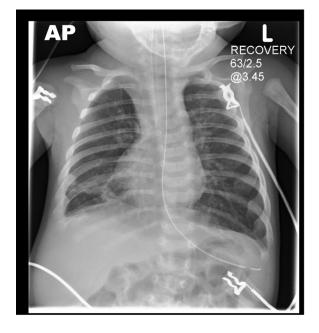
Plain chest radiograph showing hyperinflation of both lungs, atelectasis of right lower lobe with bilateral perihilar peribronchial thickening, likely related to viral bronchiolitis. Endotracheal tube in place. The foetal heart is normal situs.
